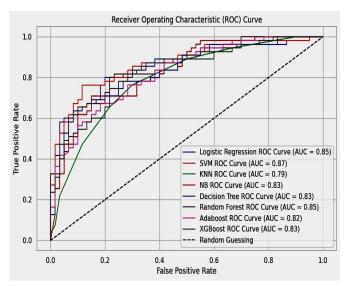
ROC/AUC of the models in predicting CT Findings
